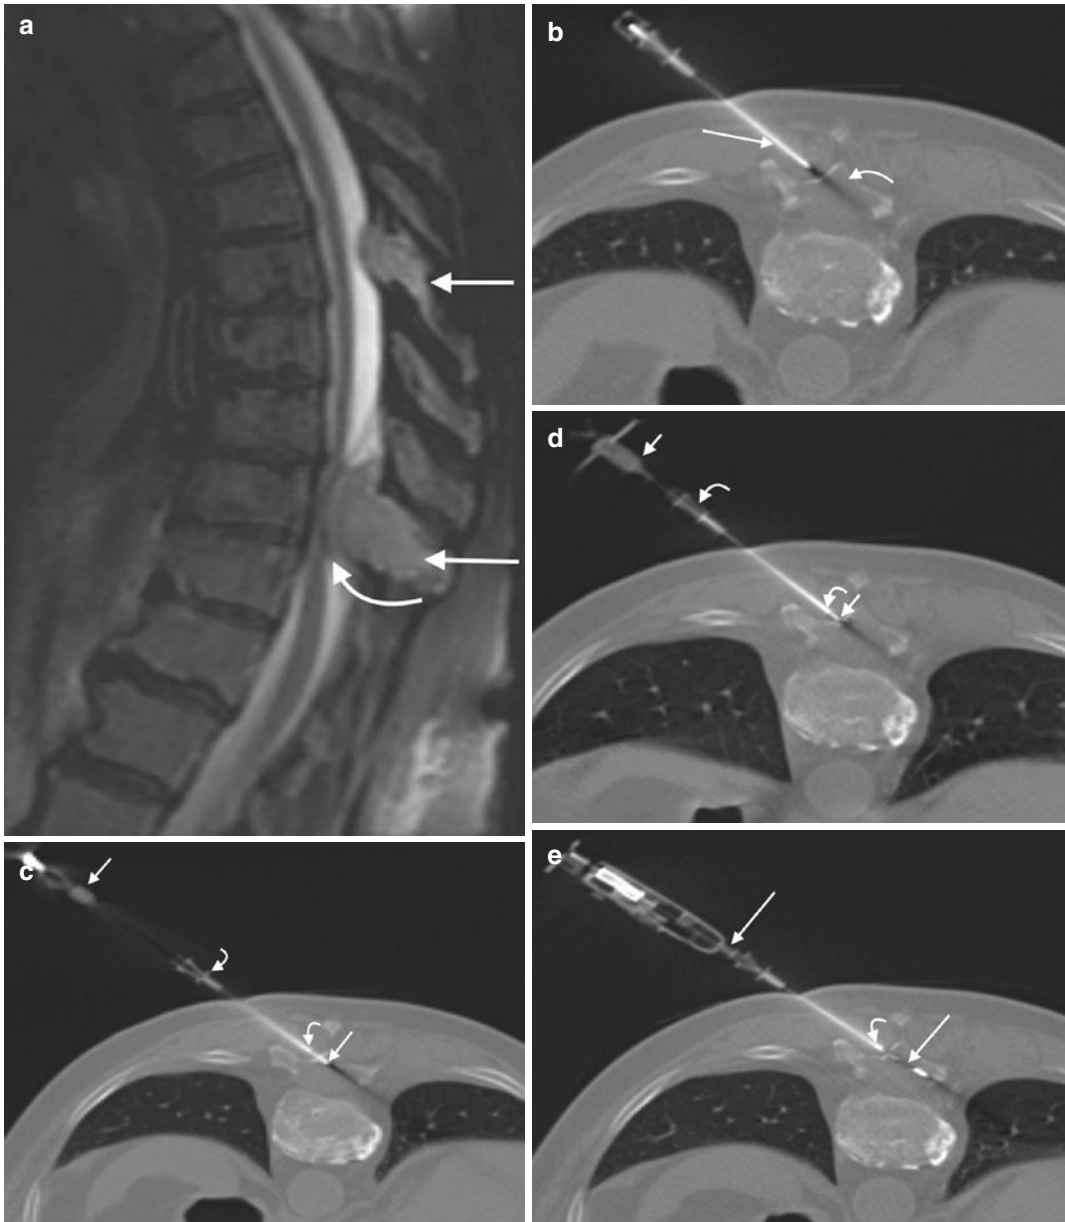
An 82-year-old female with back pain. T2-weighted sagittal image (a) shows two spinous process lesions (arrows); the large lesion impinges upon the spinal cord (curved arrow). Axial CT image (b) shows placement of a guide cannula (arrow); note the orientation of the guide cannula relative to the expansile lesion within the laminae and base of the spinous process (curved arrow). Axial CT
